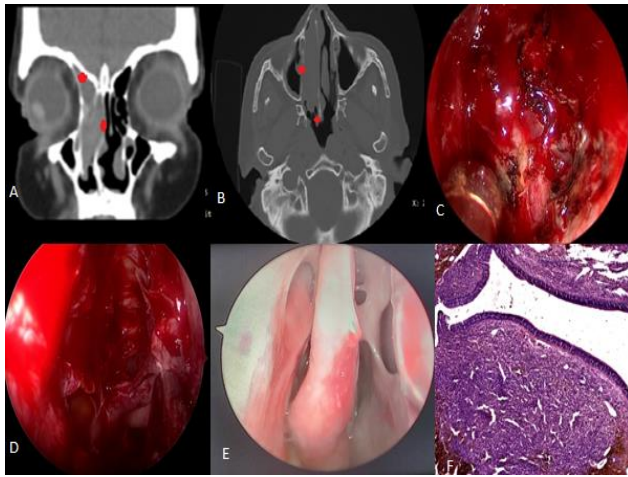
(A-F): Image showed coronal CT PNS, axial CT PNS and intra operative image, 2 months postoperative DNE image and HPE.
